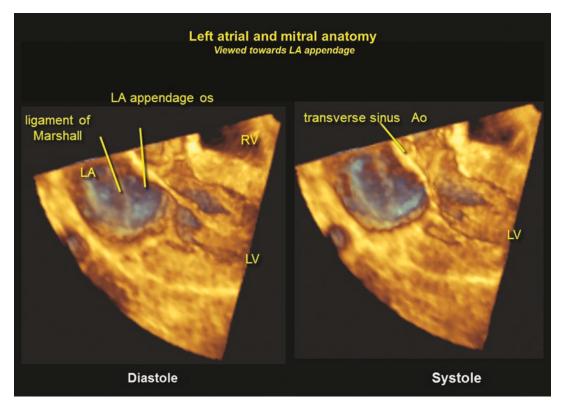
Three-dimensional echocardiogram of the heart from a similar perspective of the cut section seen in the previous figure. Pulmonary atrial veins, ligament of Marshall and the os of the atrial appendage are seen
